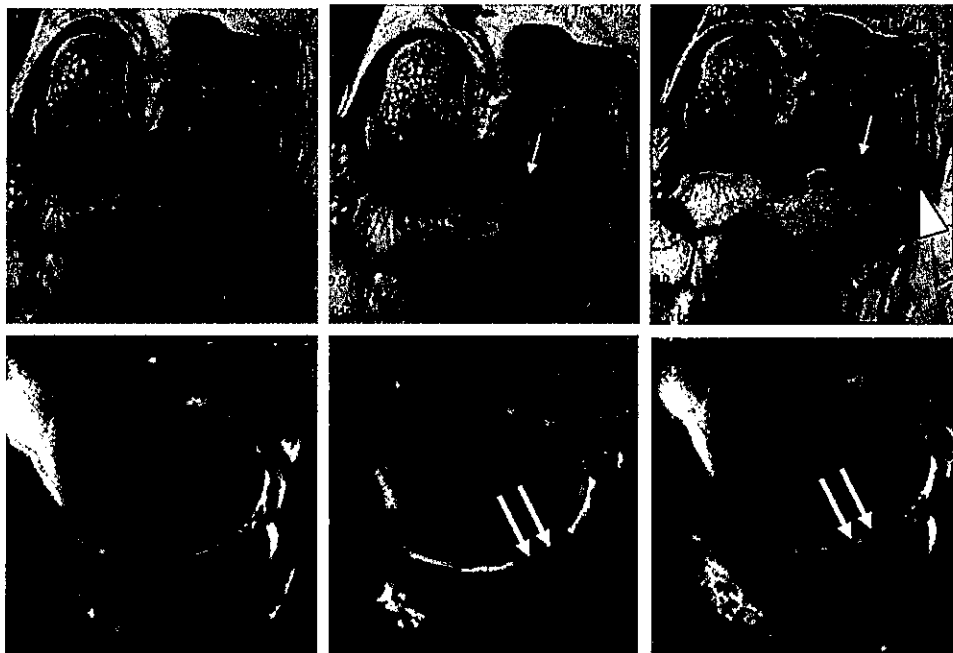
Meniscal instability as a cause of incident OA. The upper row shows coronal intermediate-weighted non-fat-suppressed MRIs over 2 years; the lower row shows corresponding sagittal intermediate-weighted fat-suppressed MRIs of the medial compartment. The left column depicts normal meniscal and cartilage integrity. The middle column (12-month follow-up images) shows an incident root tear of the medial-posterior horn (small arrow). The corresponding sagittal image shows superficial cartilage thinning adjacent to the meniscus (thick arrows). The upper right image (24-month follow-up) shows widening of the meniscal tear (small arrow) and increasing medial meniscal subluxation (arrowhead). The corresponding sagittal image shows perimeniscal cartilage thinning. Radiographic OA was diagnosed at month 24.
